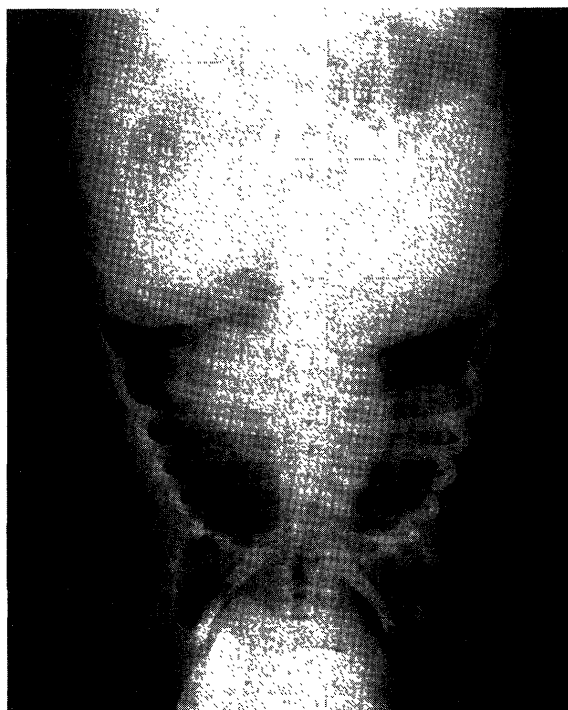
Ventrodorsal radiograph of the thorax. An area of increased density approximately 10 mm in diameter was noted in the right apical lobe.
